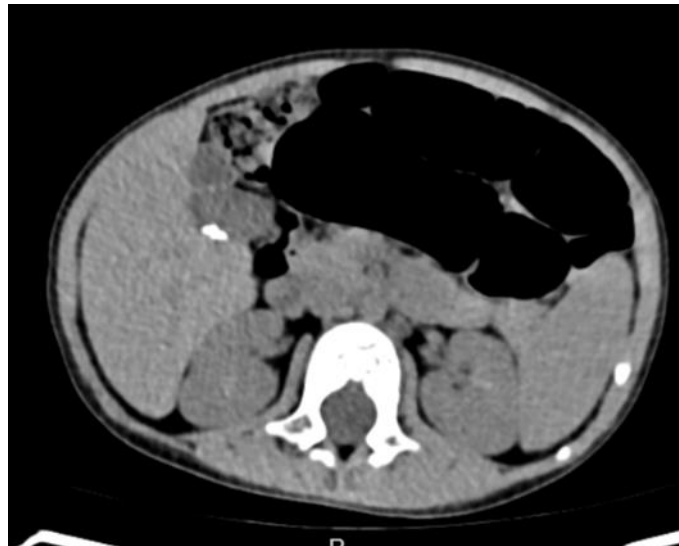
The image of the patient's gallbladder on computed tomography
